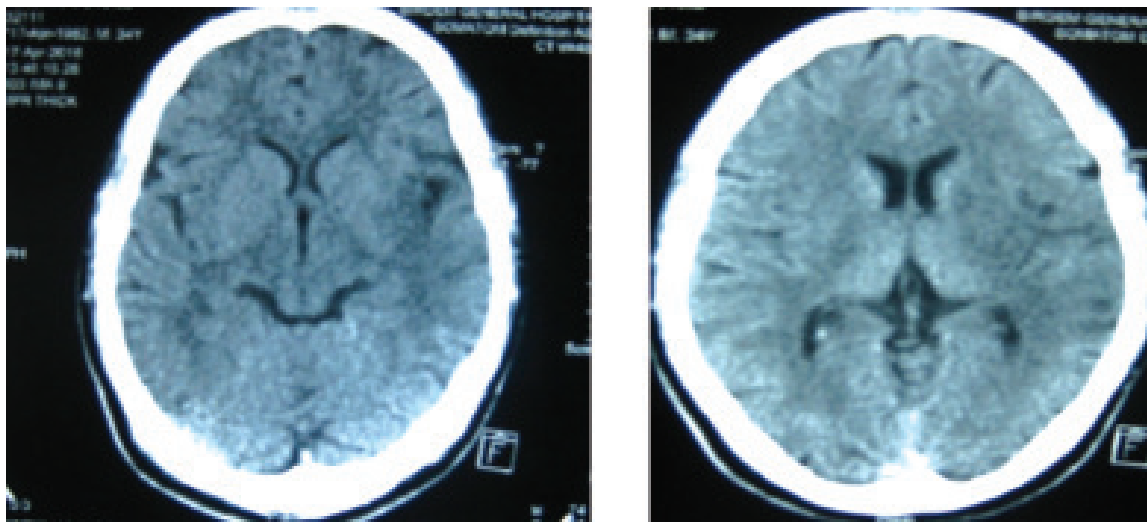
CT Scan Brain showing the loss of 'insular ribbon' sign on left cerebral hemisphere
